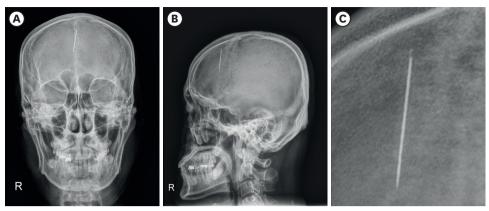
Skull X-ray that shows the foreign material in the cranium. (A) Anteroposterior view, (B) lateral view, and (C) needle head clearly seen in magnification.
